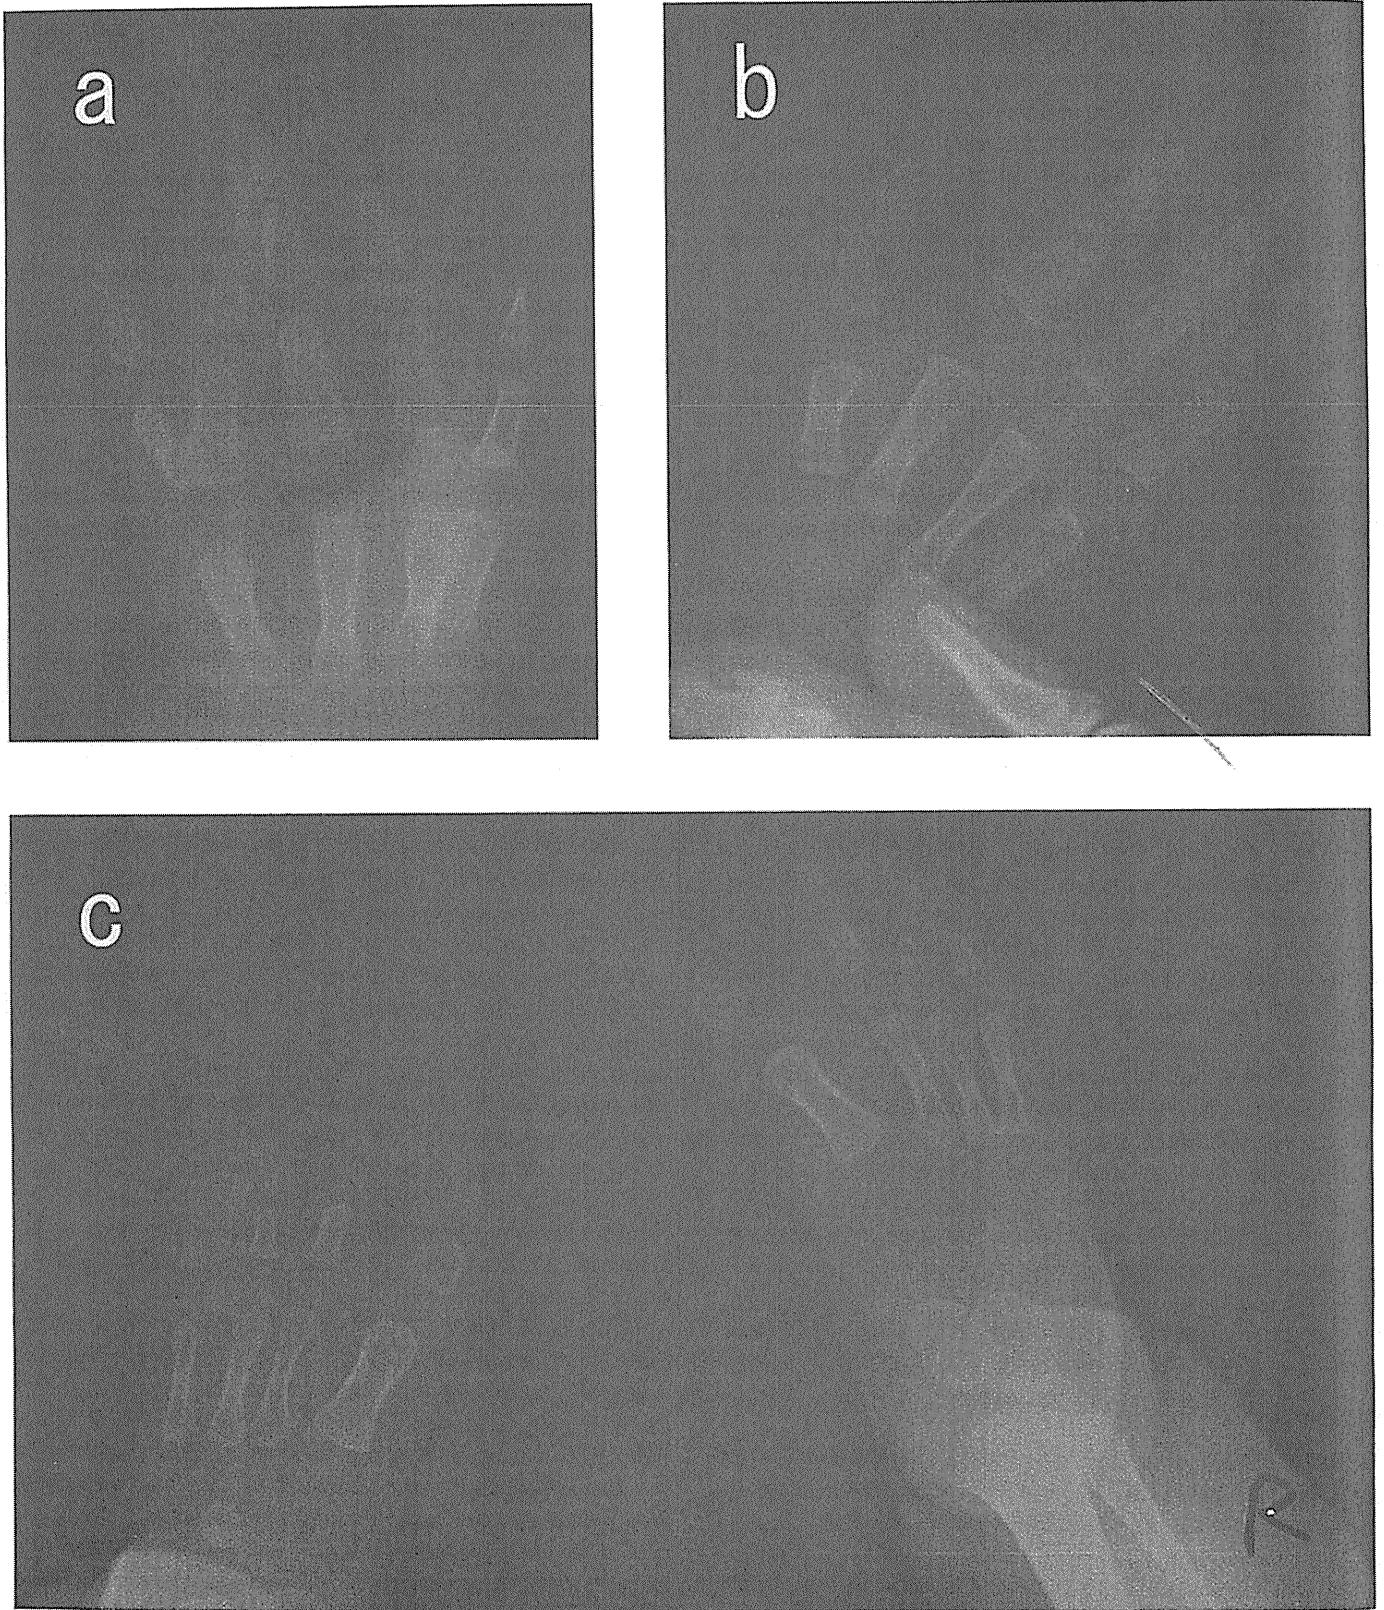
(a) X-ray findings of left hand. The fifth metacarpal bone is absent, and the fourth and fifth proximal phalanges are fused. (b) Aplasia of the fifth digit in the right hand. (c) Both feet showing absence of the fifth metatarsal bone.
